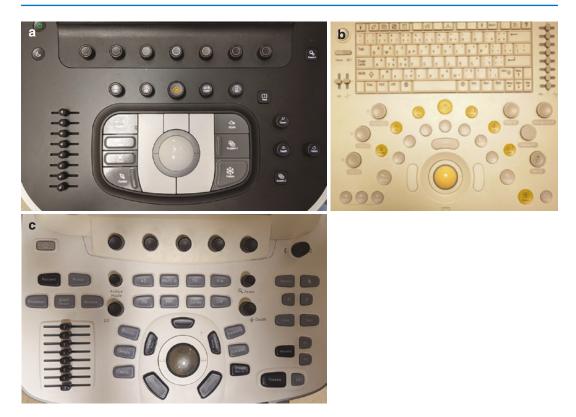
Various ultrasound system keyboards. (a) Philips EPIC CVx; (b) Philips CX50; (c) GE Vivid E9
